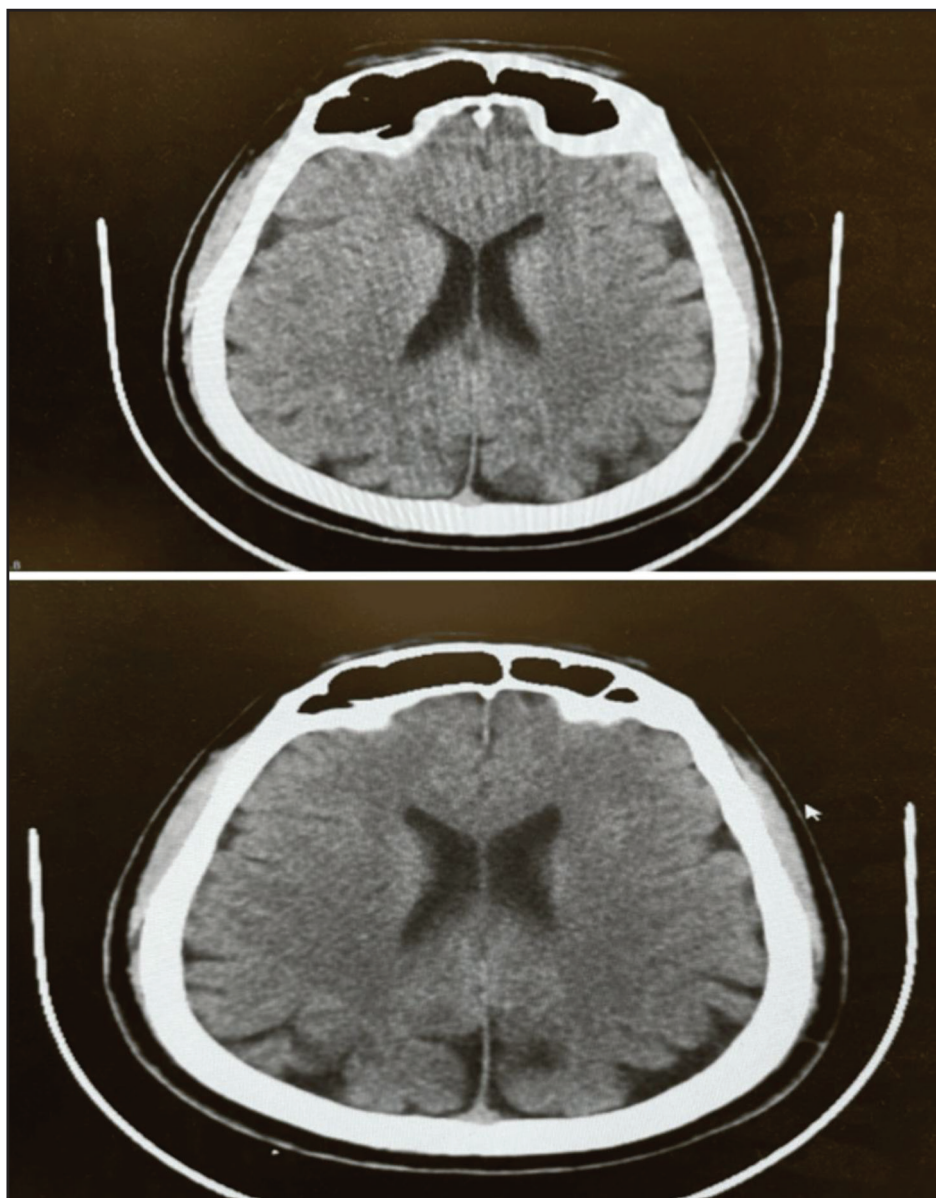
Head computed tomography.
